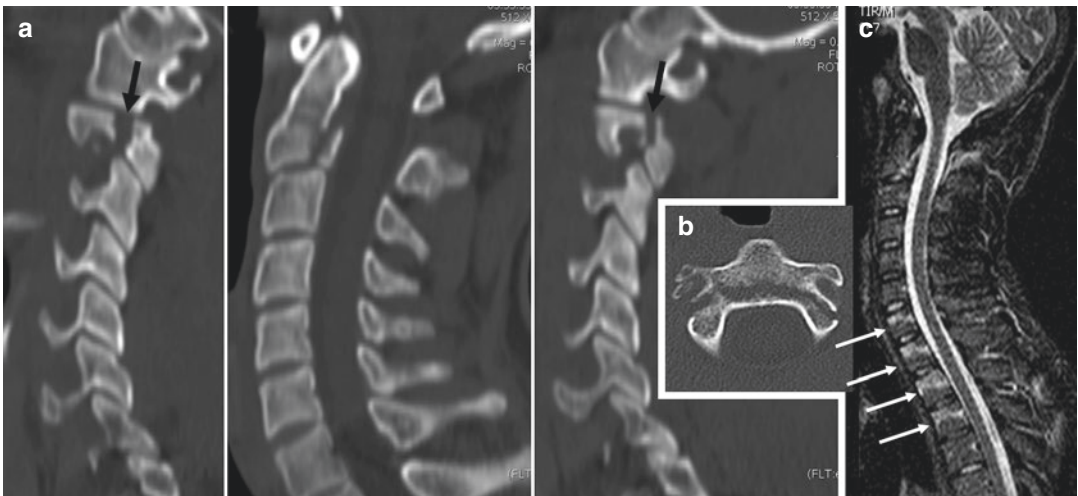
C2 atypical traumatic spondylolisthesis in multiple vertebral injuries: nonconsecutive right to left 2D-reformatted sagittal (a) and source axial (b) CT images, and STIR sagittal MR image (c). The fracture line
